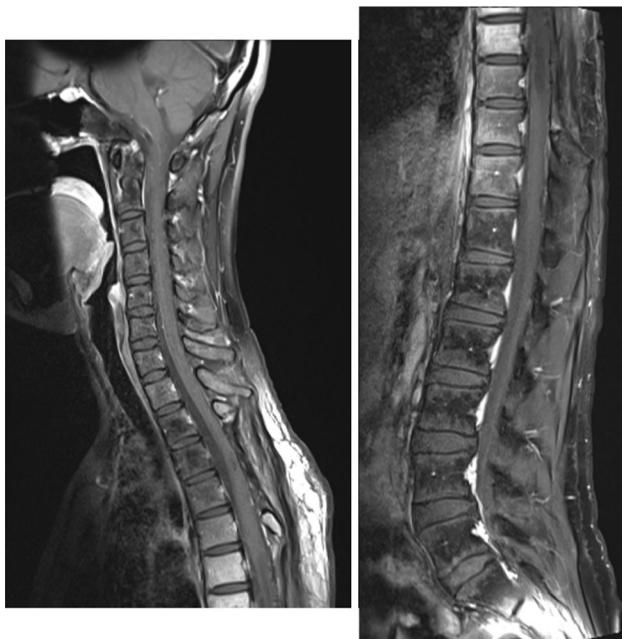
No enhanced lesion indicating recurrence or dissemination was detected on sagittal MRI of the spinal cord using gadolinium contrast agent at 3 years after the operation
